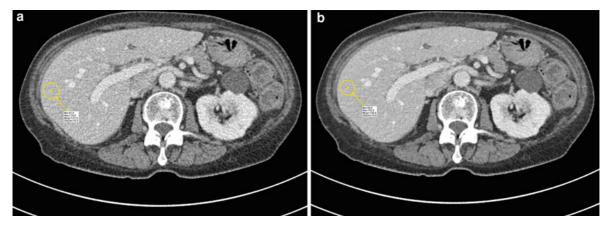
Iterative reconstruction. Transverse CT images obtained at 100 kVp and 71 effective mAs (entire abdomen and pelvis at portal phase: DLP = 139 mGy cm) in a 60-year-old woman weighing 60 kg with metrorrhagia. a Transverse
